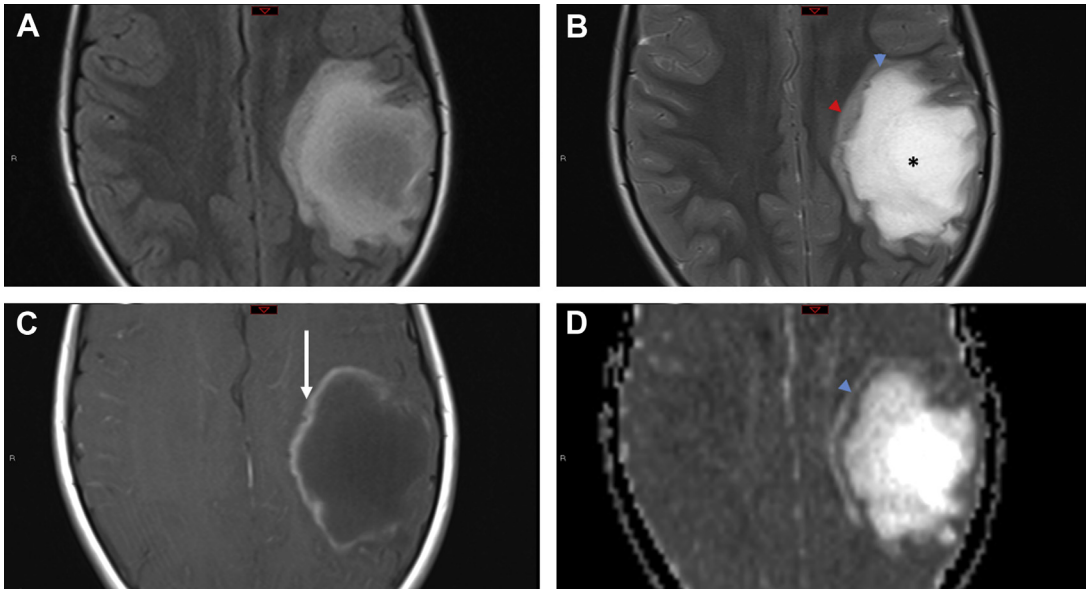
Tumefactive demyelinating lesion in ADEM. Axial FLAIR (A), axial T2-weighted (B), axial postcontrast T1-weighted (C), and axial apparent diffusion coefficient (ADC) map (D) MR images in an 8 year old with complaints of foot numbness and progressive clumsiness determined to have ADEM. The leading edge of demyelination is characterized by the incomplete rim enhancement (*white arrow* in C) with corresponding thin linear T2 and ADC hypointensity (*blue arrowheads* in B and D, respectively). The T2 images show a characteristic “zoned” appearance with the central lesion showing marked hyperintensity (*asterisk* in B), which is margined by the leading edge of demyelination (*blue arrowhead* in B) that separates the central lesion from a rim of perilesional edema (*red arrowhead* in B).
